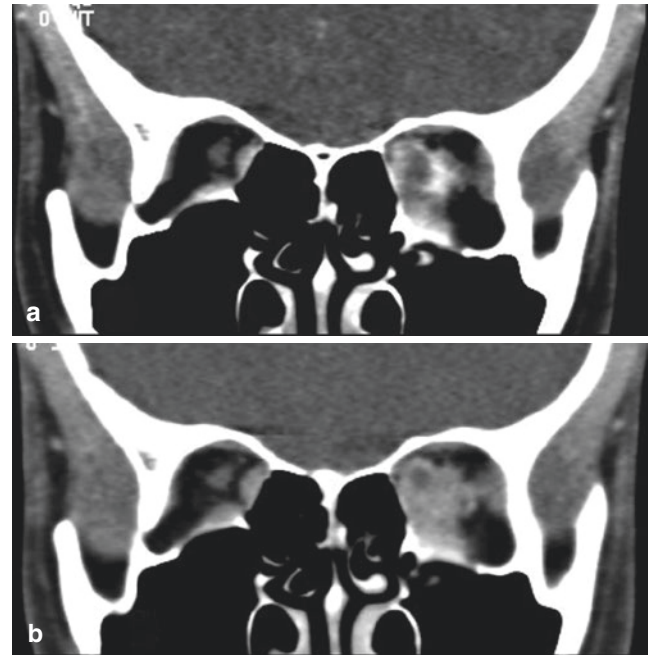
Contrast-enhanced coronal CT showing a left intraconal lesion with irregular margins before (a) and increasing in size after (b) Valsalva manoeuvre. It is wrapped around the optic nerve and inseparable from medial and inferior rectus muscles. Note the remodeling of the orbit on the left side
